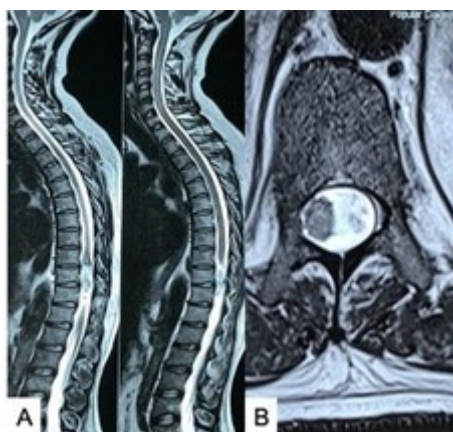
(A,B) MRI dorsal spine (T2W sagittal and axial images) showing intradural–extramedullary tumour (schwannoma). Source: Figure by authors.
